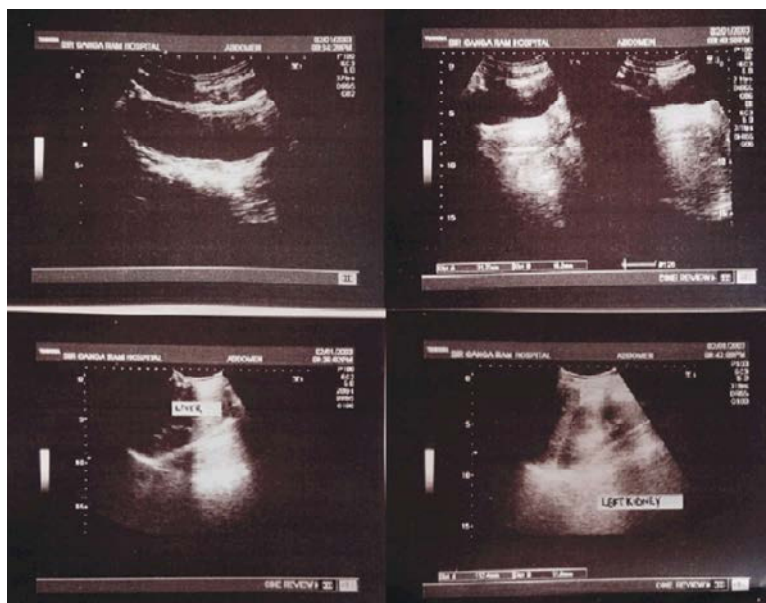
(a) Transverse ultrasound image showing absence of uterus between bladder and rectum (b) Demonstrates normally visualized left ovary with non-visualization of ovarian tissue in right adnexal region (c) Demonstrates absent right kidney in hepatorenal fossa, (d) With normally visualized left kidney.
